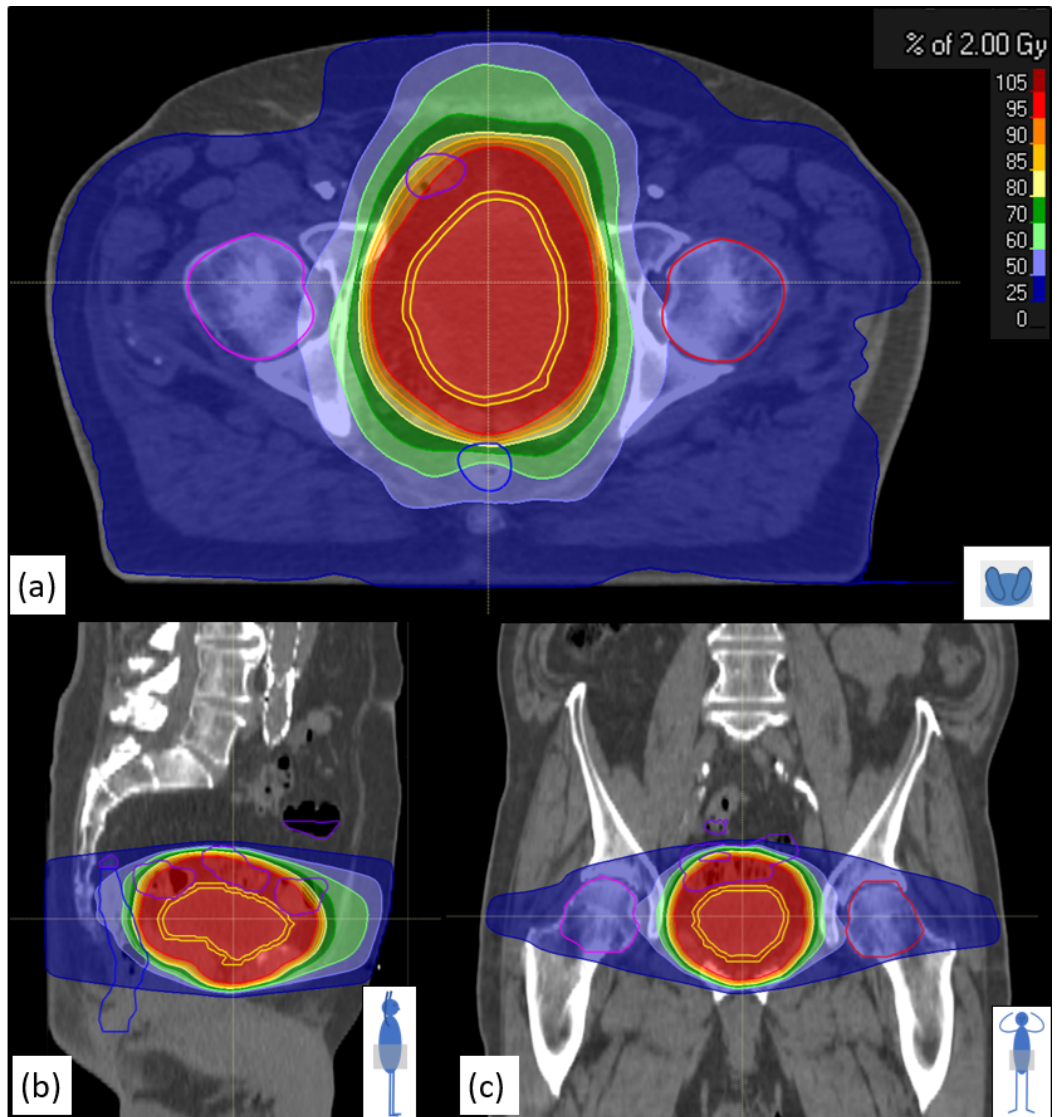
Original planned dose distribution calculated on the planning CT for a single (2 Gy) fraction using the standard 64 Gy plan. Images show (a) transaxial, (b) sagittal and (c) coronal views.
